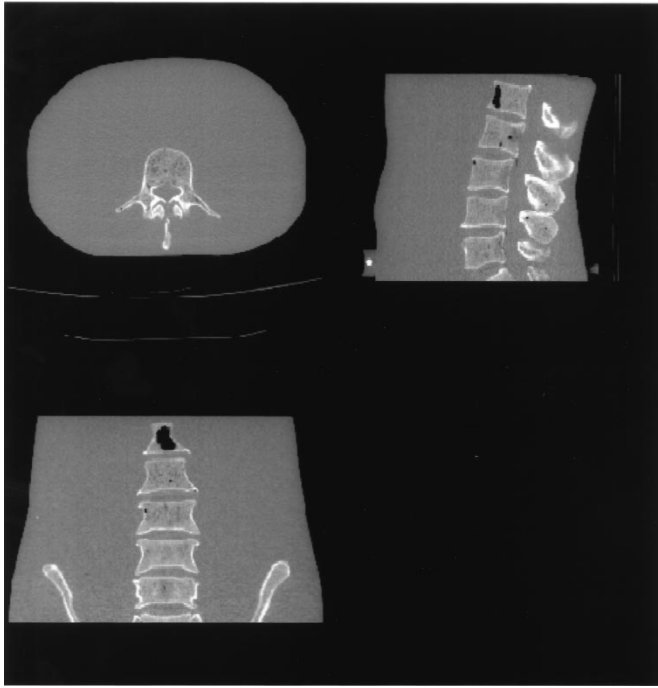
Reformatted axial (top left), sagittal (top right) and coronal (bottom left) slices from a CT image of a lumbar spine embedded in an acrylic matrix. Note one of the fiducial markers is visible in the sagittal slice.
